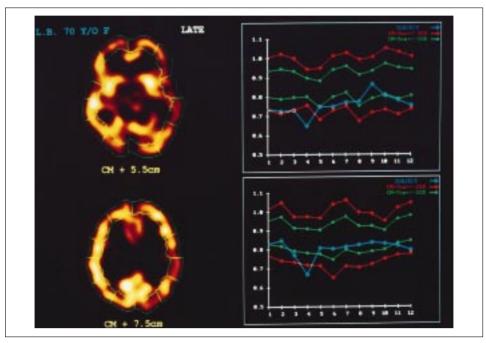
(e) Tc-99m HMPAO brain SPECT scan sections from the two month post-stroke scan presented in the format described for figure 2d. The semi-quantitative profile for the level canthomeatal +5.5 cm shows further reduction of left temporal blood flow (region 4) and the right frontal blood flow (region 12). At canthomeatal +7.5 there is also further reduction of regional blood flow at the left parietal lobe (region 4).
